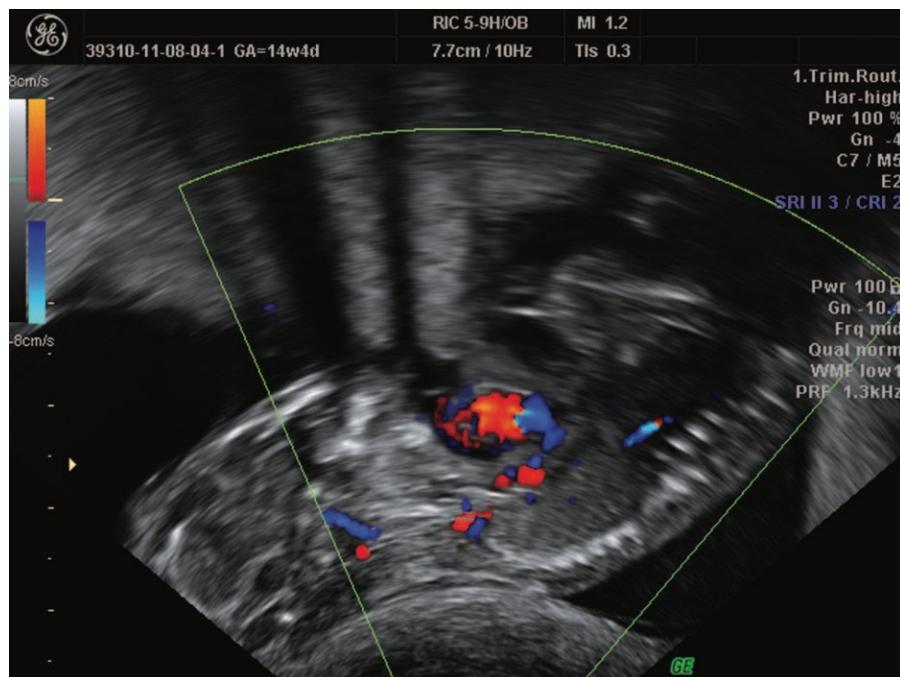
Ultrasound diagnosis of *ectopia cordis* (personal data)
